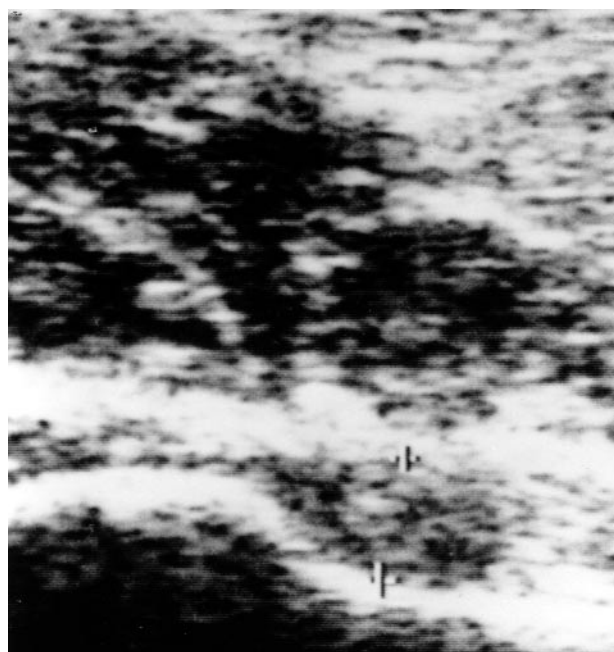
Ultrasonography of a hip from a patient with JRA. The joint capsule is distended, and the distance between the femoral neck and joint capsule shown by the 2 markers is 0.75 cm.
